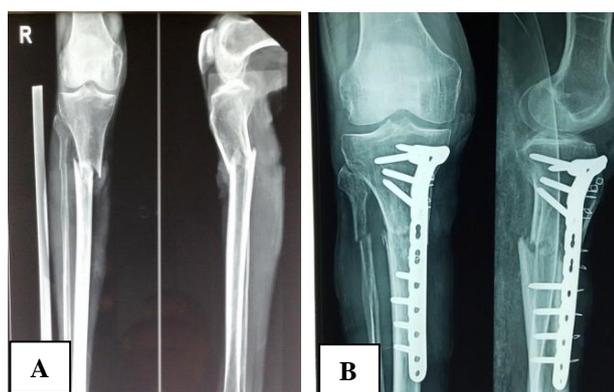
A=Preoperative radiograph showing proximal tibial extraarticular fracture; B=Radiograph showing fracture fixed by plate and screws.
